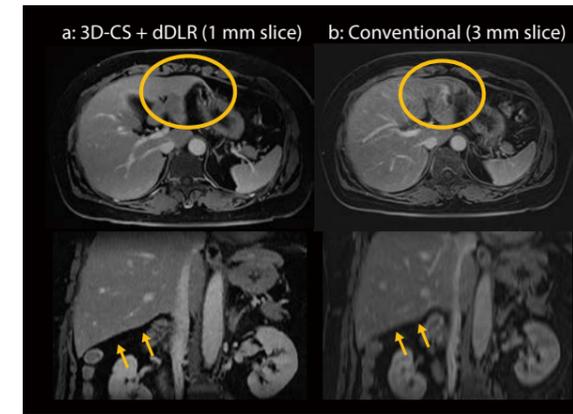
Dynamic abdominal MRI using the conventional method and 3D-CS+dDLR (WIP)
